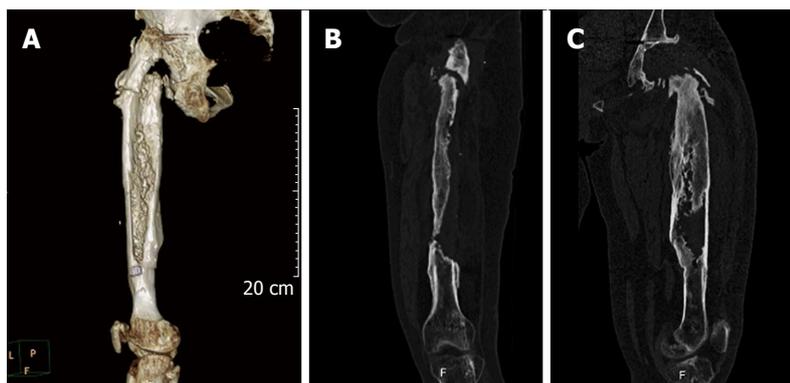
Computed tomography scan images with metallic artifact subtraction and three-dimensional reconstruction consist a useful tool for precise assessment of the amount of bone loss and the specific variations of the femoral anatomy preoperatively. A: Computed tomography scan image of the left femur (posterior projection) with metallic artifact subtraction and three-dimensional reconstruction showing precisely the amount of bone loss of the proximal part of the femur; B: Coronal; C: Sagittal view of the same case.
